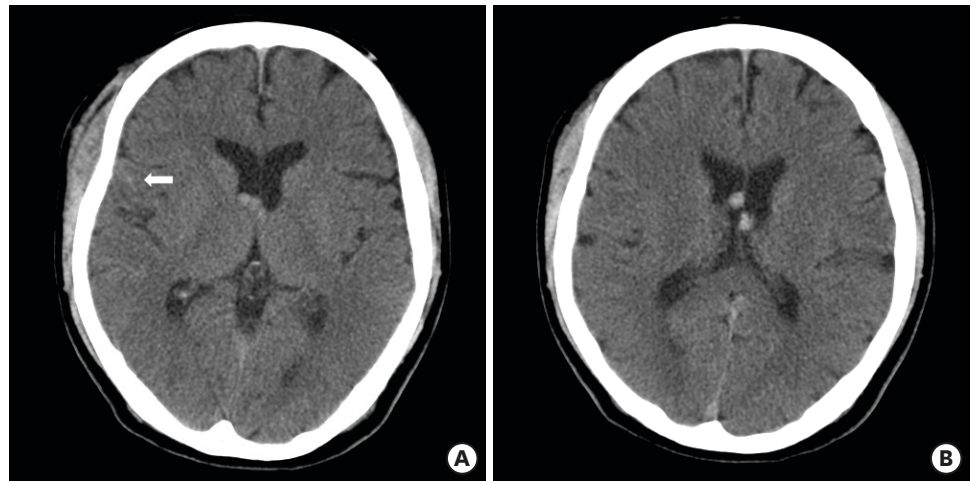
A cranial computed tomography scans performed 30 minutes after the injury reveal small amounts of traumatic intraventricular hemorrhages in the frontal horn and body of bilateral lateral ventricles. High-density spot suggesting traumatic intracerebral hemorrhage in the right temporal lobe are noted (white arrow).
